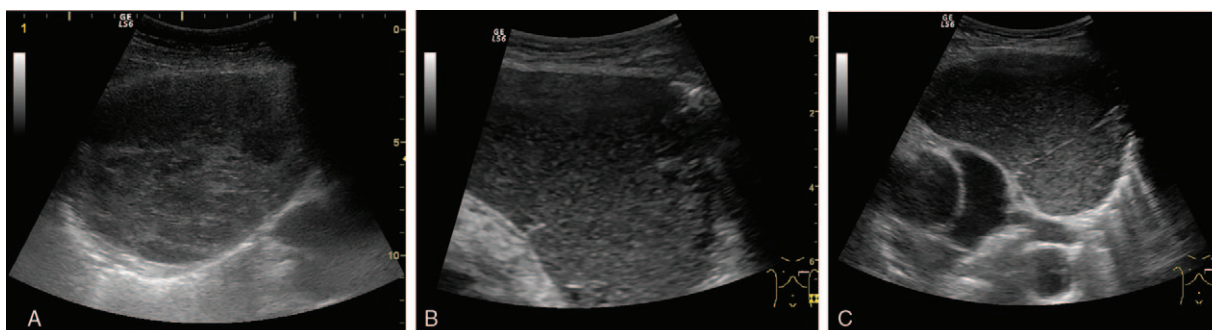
A, Ovoid-shape slight inhomogeneous hypoechoic tumor surrounded by ventilated lung—right parasternal approach of thymoma. B and C, Cystic lesion with floating echoes, thin walls, and small hypoechoic solid component—cystic thymoma adjacent to the pulmonary trunk and left pulmonary artery.
